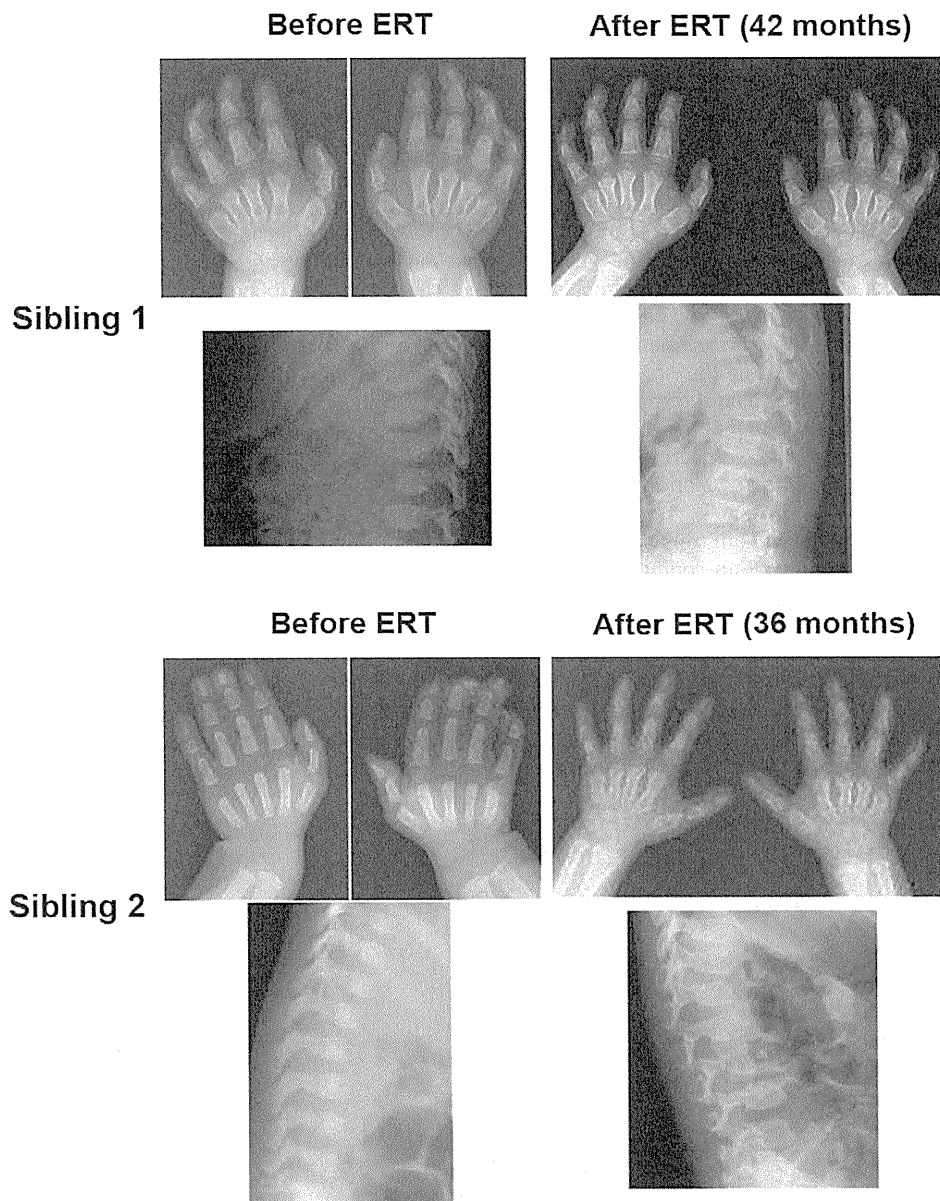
Radiograph of hands and spinal column at baseline and after ERT in two siblings.
